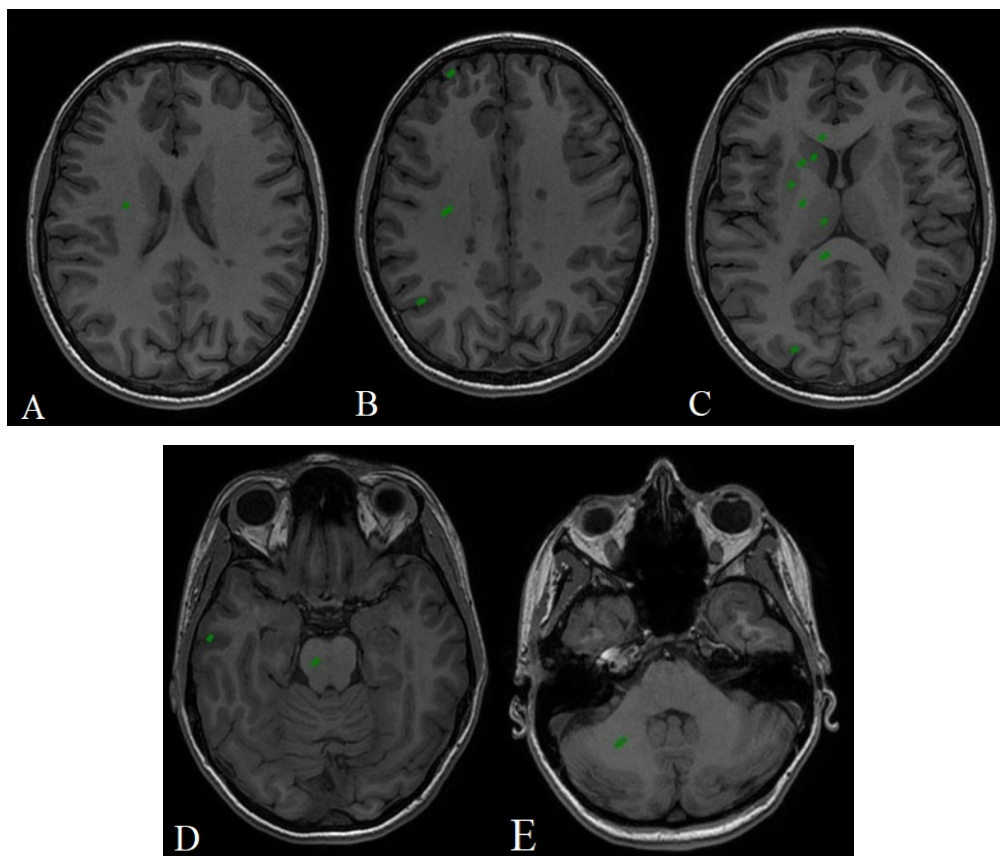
Pre-contrast T1-weighted magnetic resonance images in a 50-year-old man with multiple sclerosis at the initial scan. Standard regions of interest were set in 16 different anatomical regions of the brain: the white matter of *corona radiata* (A), cortex of the frontal and the parietal lobes, white matter of *centrum semiovale* (B), cortex of the occipital lobes, *nucleus caudatus*, *putamen*, thalamus, anterior and posterior horn of the *capsula interna*, *genu* and *splenium* of the *corpus callosum* (C), cortex of the temporal lobes, *substantia nigra*, *pons* (D), and cerebellar hemisphere (E).
